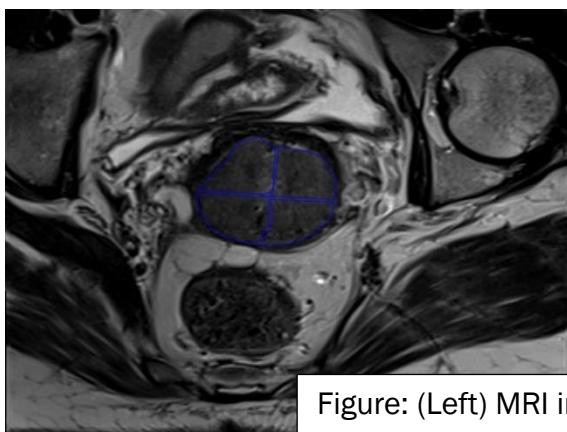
(Left) MRI imaging; (right) PET CT image
